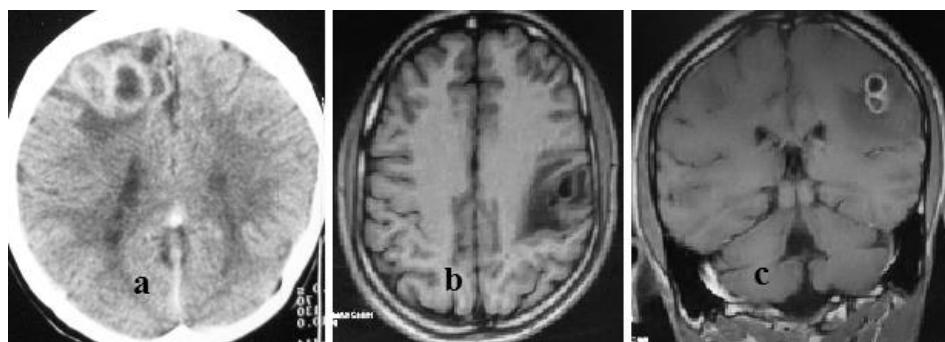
Brain toxoplasmosis in a patient with HIV/AIDS. a. CT showing multiple ring-enhancing lesions in the right cerebral cortex. b. Transverse and, c. coronal sections of brain T1-weighted MRI in another patient showing ring lesions with surrounding oedema.
